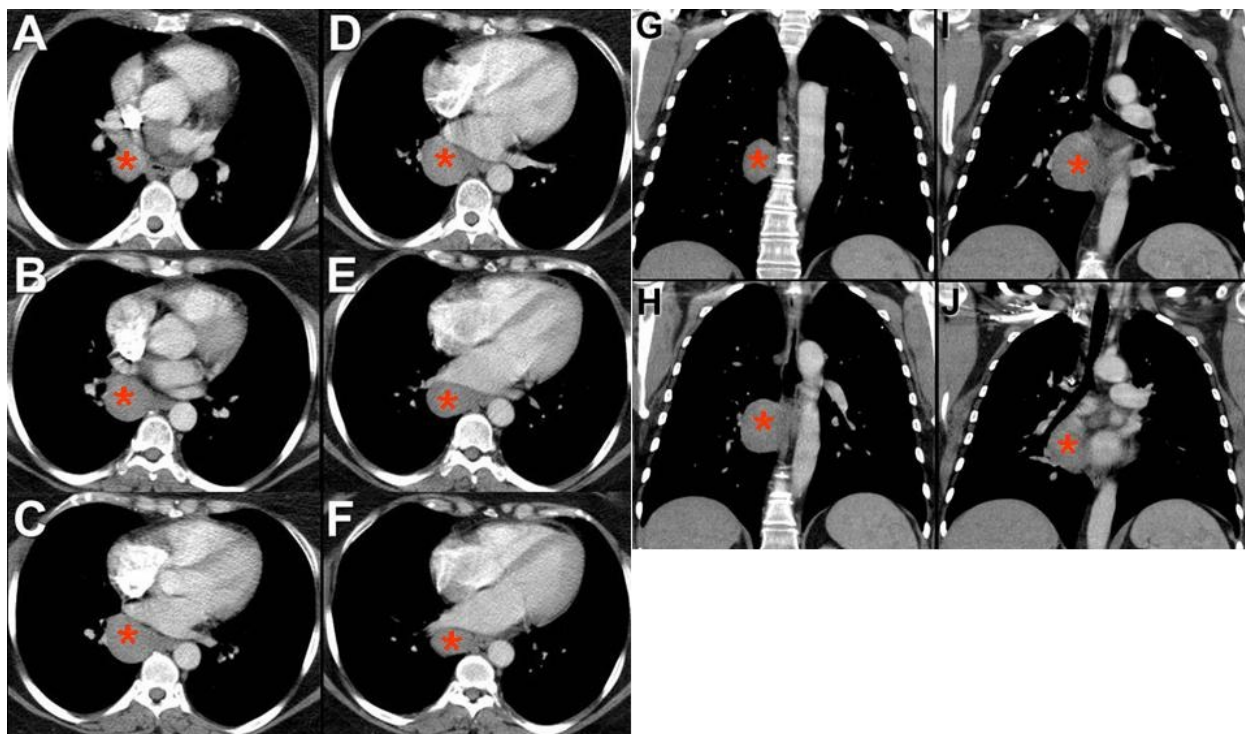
Axial (A-F) and coronal (G-J) enhanced thoracic CT shows a homogeneous mass (*) in the subcarinal region.
